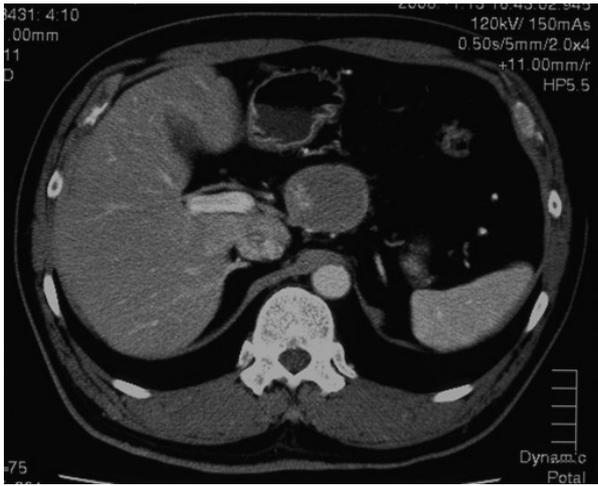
Abdominal axial CT image showing a well-circumscribed cystic lesion of 5 cm in the pancreatic body. The cystic wall and an intracystic projection showed contrast enhancement.
